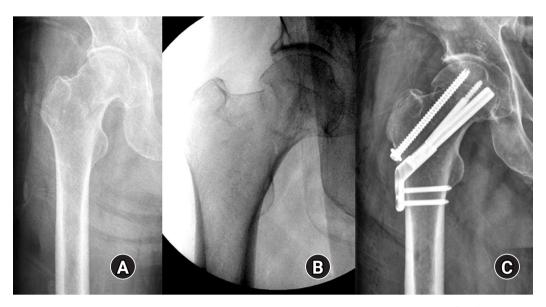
A 54-year-old male patient sustained a femoral neck fracture caused by a fall from a 2-m height. (A, B) Plain radiographs and an intraoperative fluoroscopic image show the subcapital fracture. (C) The femoral neck system anti-rotational screw was applied to increase the anchoring and stability of the femoral head fragment.
